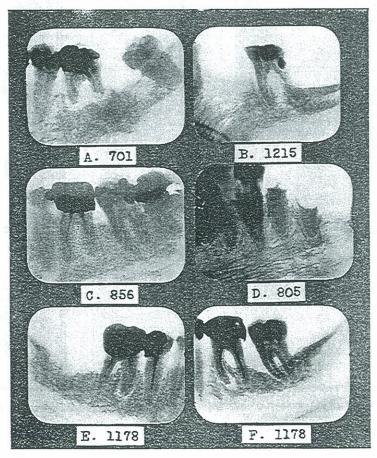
ROENTGENOGRAPHIC APPEARANCE OF CONDENSING OSTEITIS ABOUT INFECTED TEETH.
